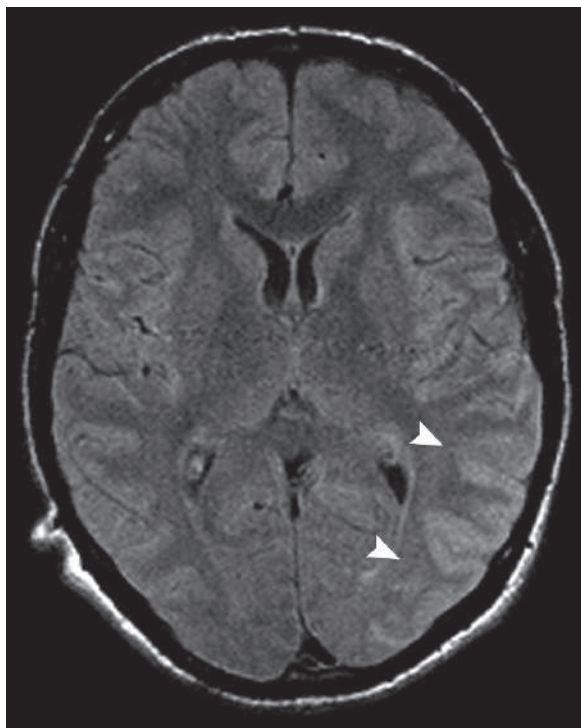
Axial FLAIR image in a child with recurrent epilepsy shows moderate hyperintense cortices in the left temporo-occipital region in a unilateral pattern (arrowheads). The patient was diagnosed later as a case of Rasmussen encephalitis (RE)
